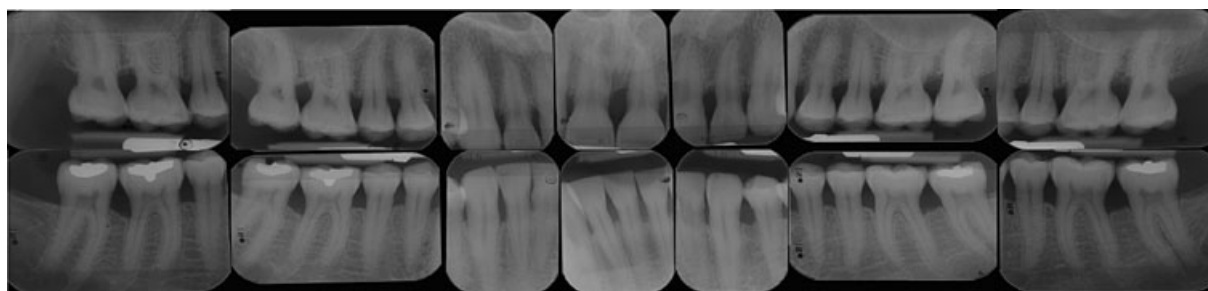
Radiographs of the patient presented in Fig. 31-17 at the final examination.
